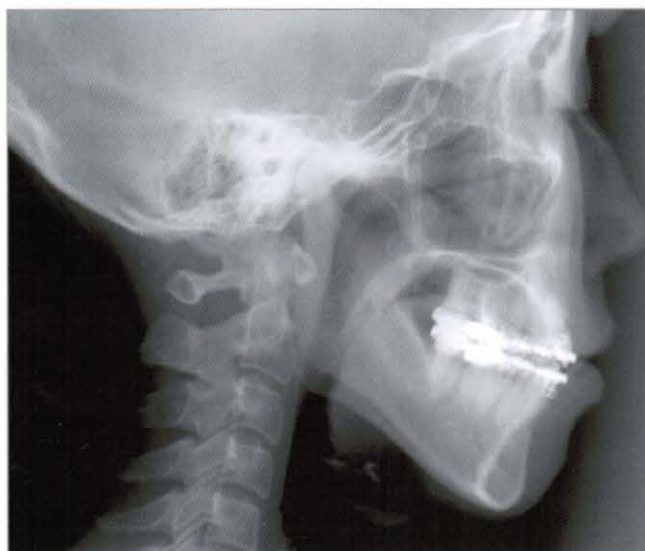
Cephalometric radiograph after space closure (2005, 4,19)
